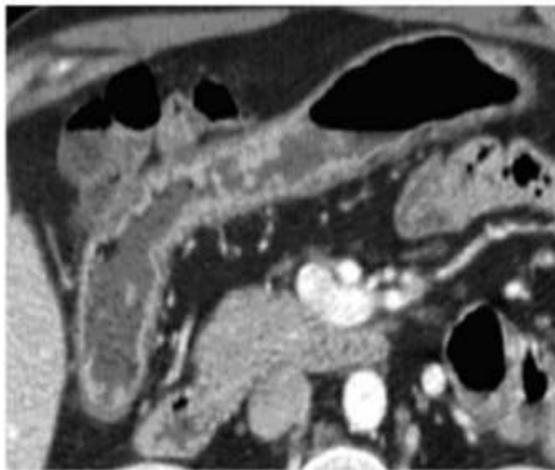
CT enteroclysis axial images showing pseudopolyps in Crohn's disease
